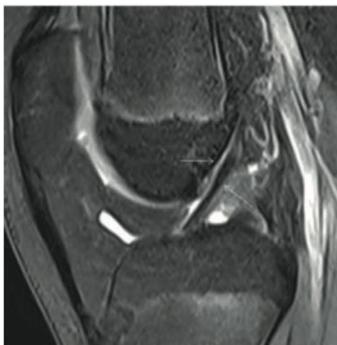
Sagittal view using fat saturation proton density (a) and T1 (b) MRI of the knee in an 11-year-old child. An area of relative increased signal intensity can be seen at the level of the posterior horn of the medial meniscus (oblique arrows). This aspect is not abnormal.
